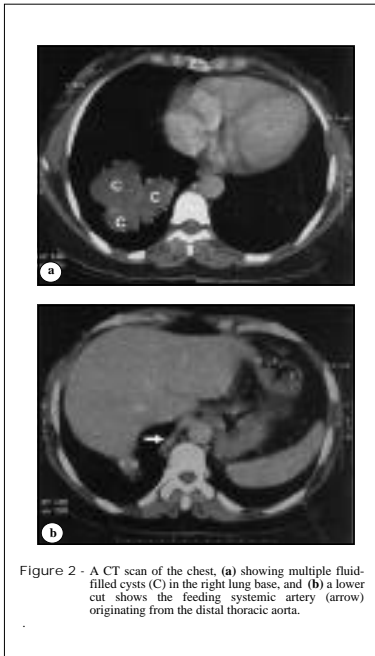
A CT scan of the chest, (a) showing multiple fluid-filled cysts (C) in the right lung base, and (b) a lower cut shows the feeding systemic artery (arrow) originating from the distal thoracic aorta.
